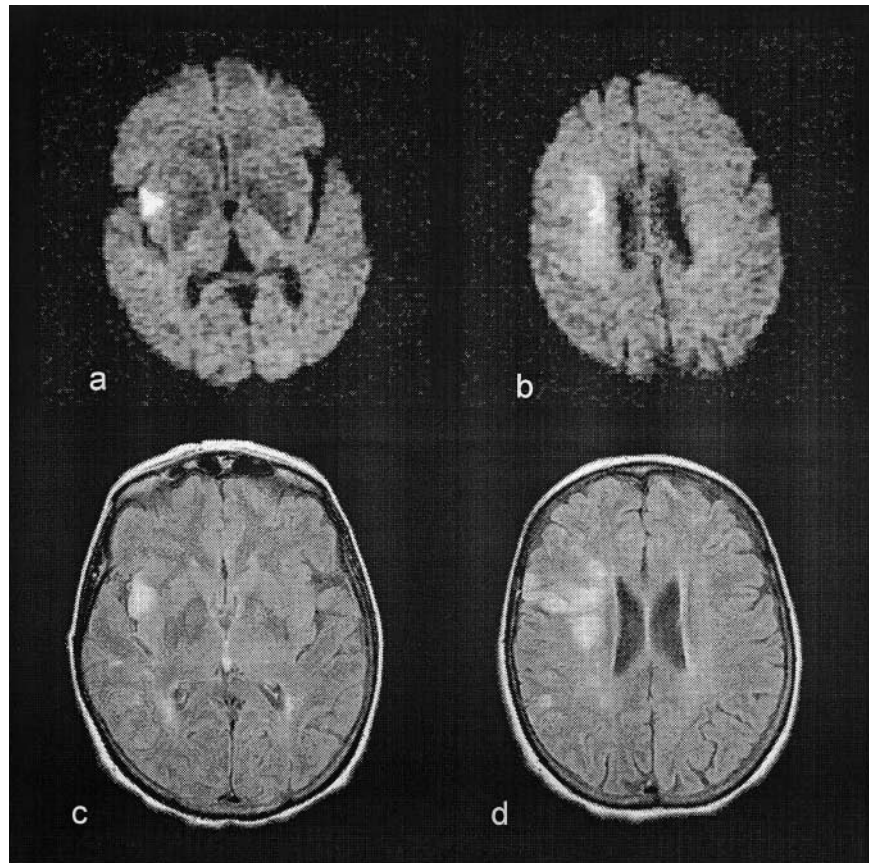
DWI examination 8 hours after symptoms onset evidenced another parietal ischaemic lesion (a, b); FLAIR images 7 days after symptoms onset confirmed the subinsular and parietal lesions (c, d)
